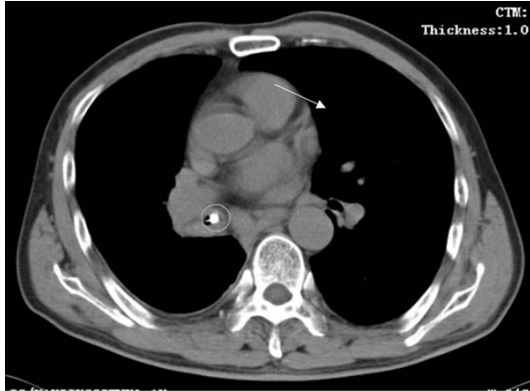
Chest CT showed an abnormal high-density shadow (white arrow) in right middle bronchus.
